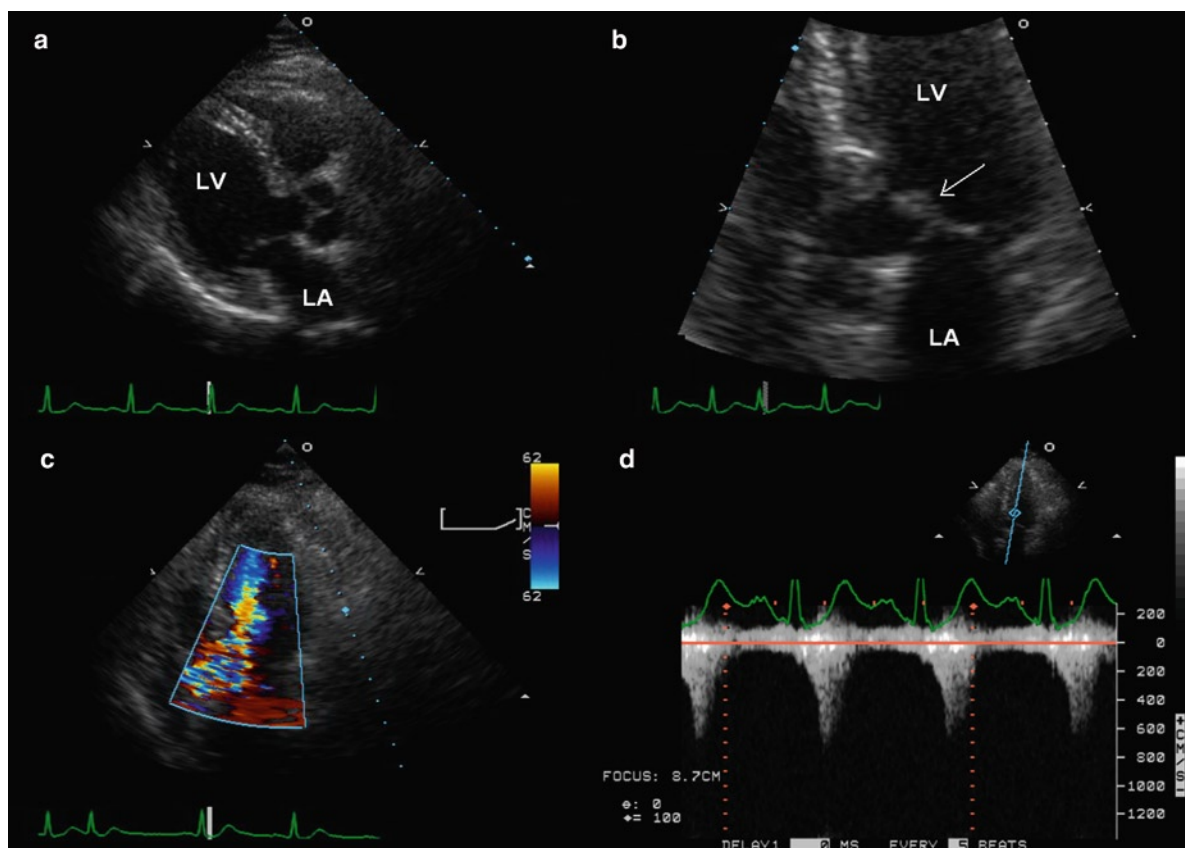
These are the parasternal long-axis (a), short-axis (b), apical four chamber (c) and apical long-axis (d) views of a 71-year-old woman. The ventricular septum is angulated with a sigmoid shape (arrow) and the left ventricular wall thickness is mildly increased. LV left ventricle
